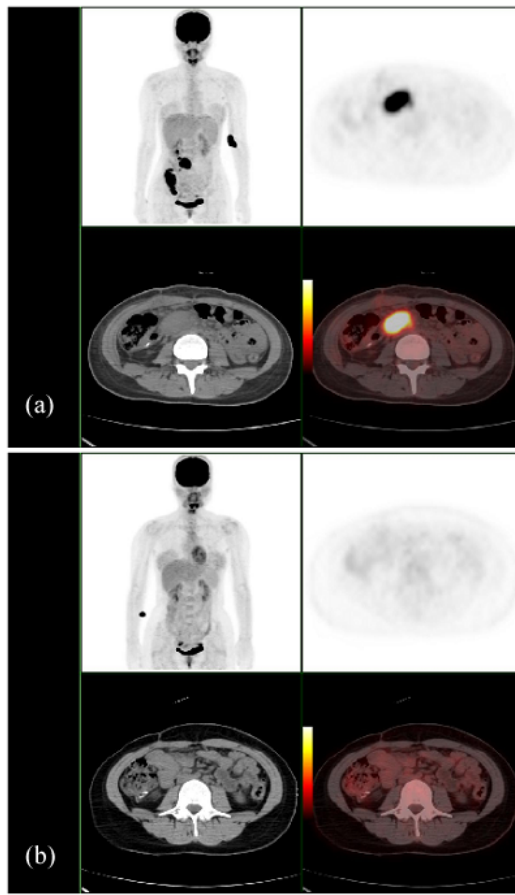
(Color online) PET/CT images of a 29 years-old female, DLBCL stage IV, Ki67 of 50%. The initial scan found mesenteric lymph nodes and right colon involvement,  $SUV_{max}$  was 21.9(a), interim PET/CT found no apparent malignant lesion and  $SUV_{max}$  was 2.0(b),  $\Delta SUV_{max}$  and  $\Delta SUV_{max}\%$  were 19.9 and 90.9%, respectively. Integrative score was 0. Although the age-adjusted IPI was high, no symptom of progression or relapse was found during the follow-up of 26 months.
